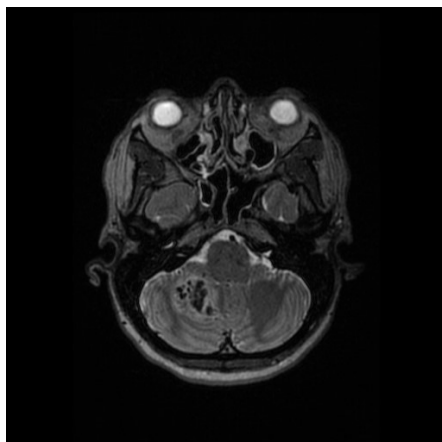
(right): Preoperative MRI image (axial-plane, T2 sequence) from the same patient. The cerebellar AVM is better visualized.
